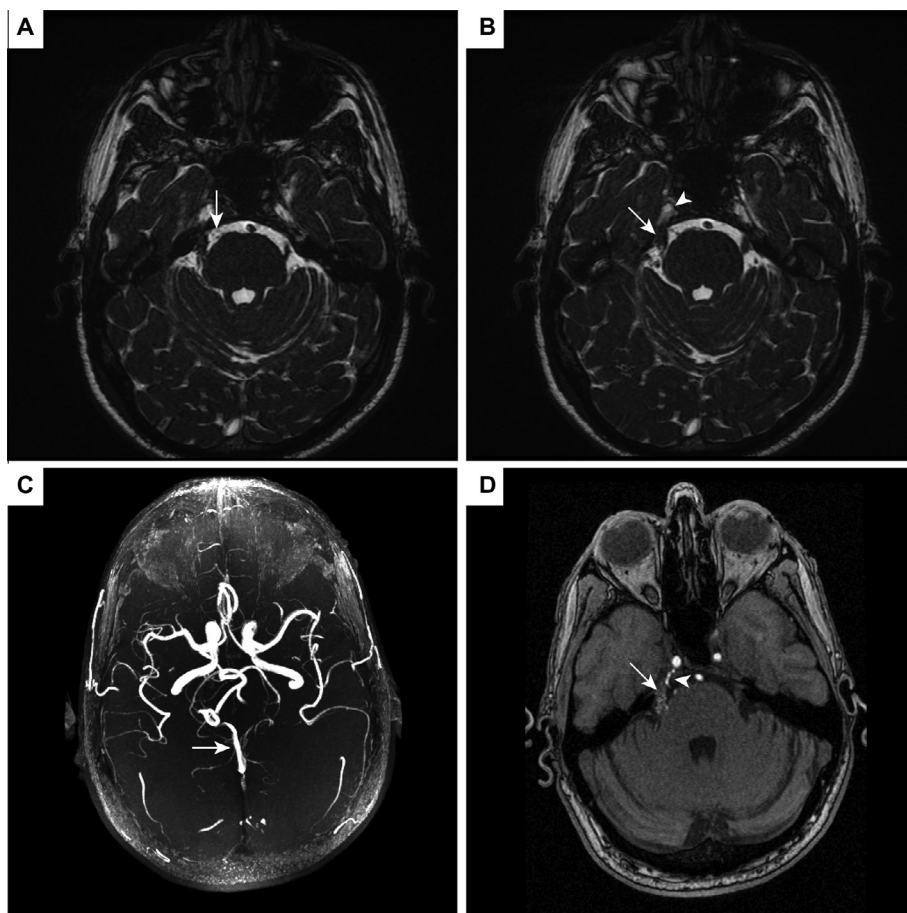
Trigeminal nerve arteriovenous malformation (AVM) identified by MRI. (A) Axial T2-weighted image at the level of the pons demonstrates multiple small flow voids (arrow) in the right lateral prepontine cistern adjacent to the right cranial nerve V. (B) Axial T2-weighted image at the level of Meckel's cave (arrowhead) demonstrates enlargement of the cisternal segment of the right cranial nerve V (arrow) proximal to the right Gasserian ganglion. (C) Axial maximal intensity projection image from brain magnetic resonance angiography (MRA) demonstrates abnormal high signal in the right basal vein of Rosenthal that is consistent with arteriovenous shunting related to the right trigeminal nerve AVM. (D) Axial image from brain MRA demonstrates a persistent trigeminal artery arising from the cavernous segment of the right internal carotid artery (arrowhead). Abnormal increased signal is present within an enlarged cisternal segment of the right cranial nerve V (arrow), which corresponds to an AVM.
